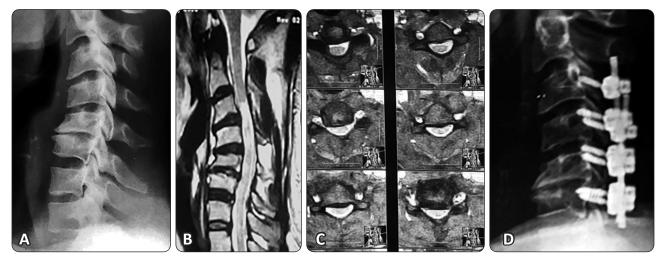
An 34-year-old man suffered from multi level cervical discs C3/4, C4/5, C5/6, C6/7, and progressive kyphosis. (A,B,C) Preoperative x ray and MRI demonstrated that the cervical canal was narrowed at c3/4 level with cord malacia. The patient underwent multilevel laminectomy and lateral mass fusion C3-C6. (D) Postoperative lateral X-ray showing satisfactory screws with facet violation at left c3 lateral mass. The patient improved clinical on JOA from 13 to 15 and Nurick DI from 4 to 5
